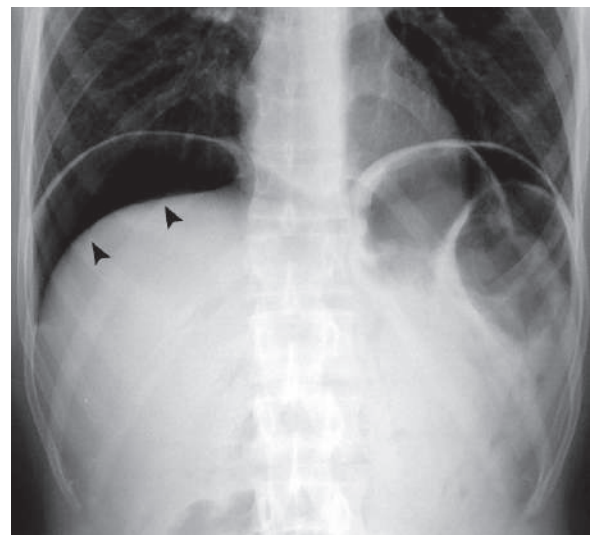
Anteroposterior plain abdominal radiograph shows collection of air under the right diaphragm due to duodenal ulcer perforation (arrowheads)
